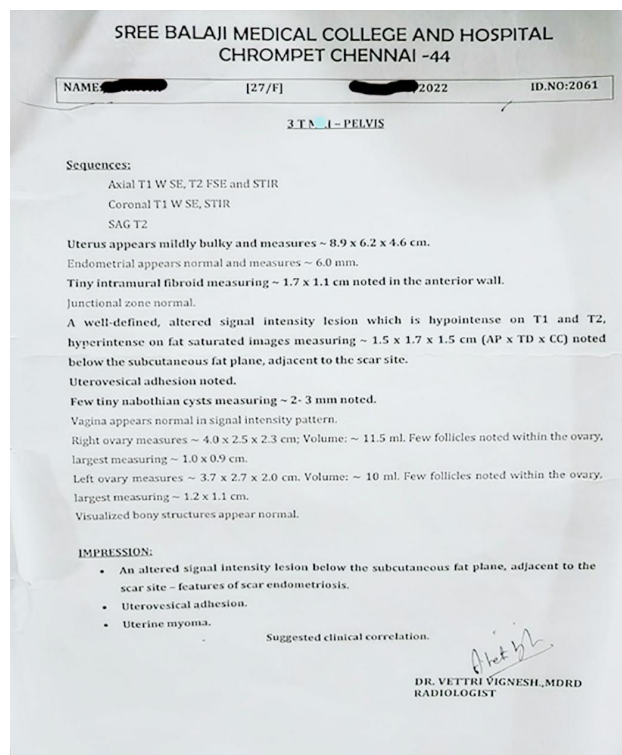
MRI report of scar endometriosis
